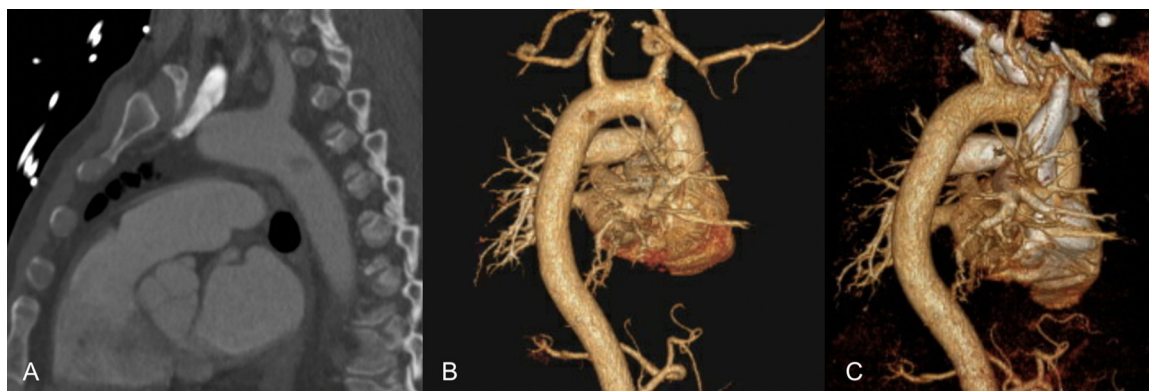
(A) Computed tomography angiography (CTA) demonstrating a mobile mural thrombus in the proximal descending thoracic aorta, just below the left subclavian artery takeoff. (B) CTA with three-dimensional vascular reconstruction re-demonstrating the thrombus location. (C) CTA with three-dimensional vascular reconstruction following percutaneous aspiration thrombectomy of the thrombus demonstrating no evidence of any residual thrombus.
